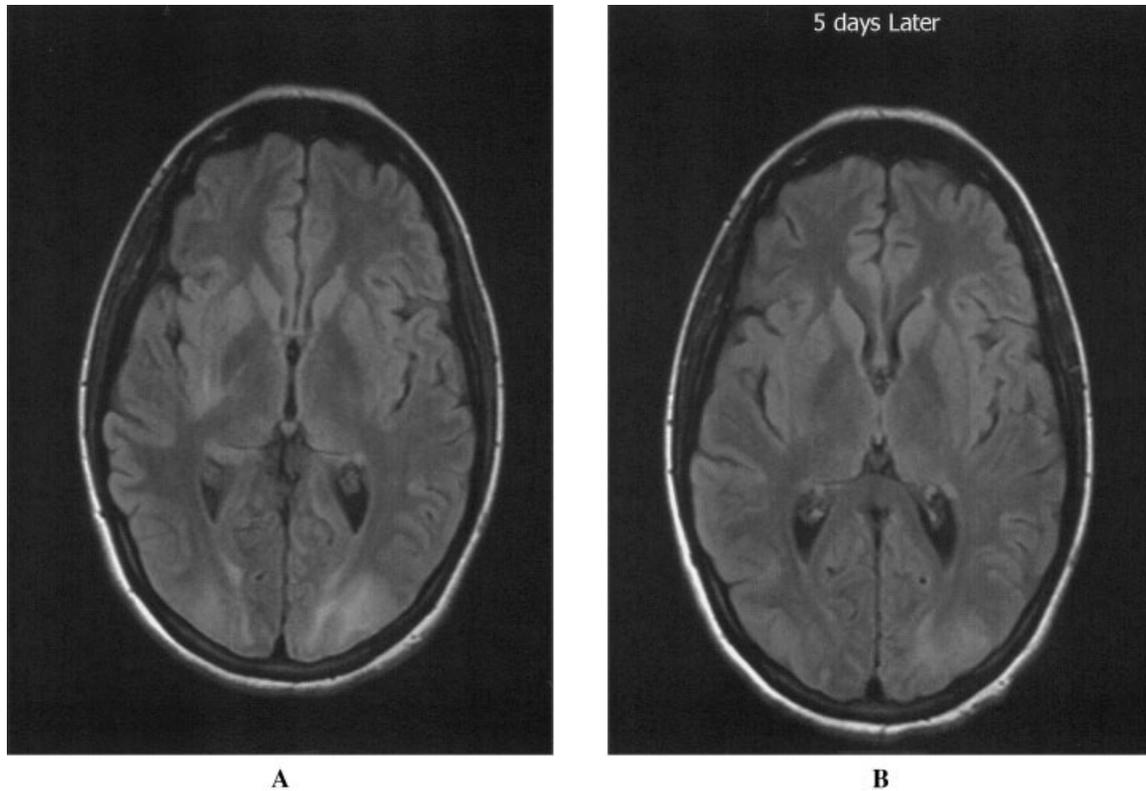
A, Brain magnetic resonance imaging scan revealing multiple nonenhancing white matter lesions confined predominantly to watershed areas on the posterior brain on the initial evaluation, and B, 5 days later.
